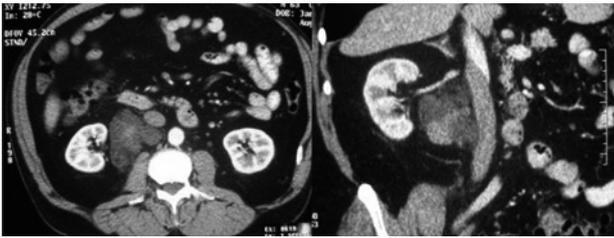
CT. Retroperitoneal mass inferior to right renal vein and displacing the vena cava. The ureter is displaced laterally (arrow).
